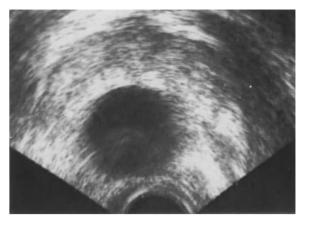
Pelvic ultrasonography. Transrectal scan in a patient with an ejaculatory duct cyst
